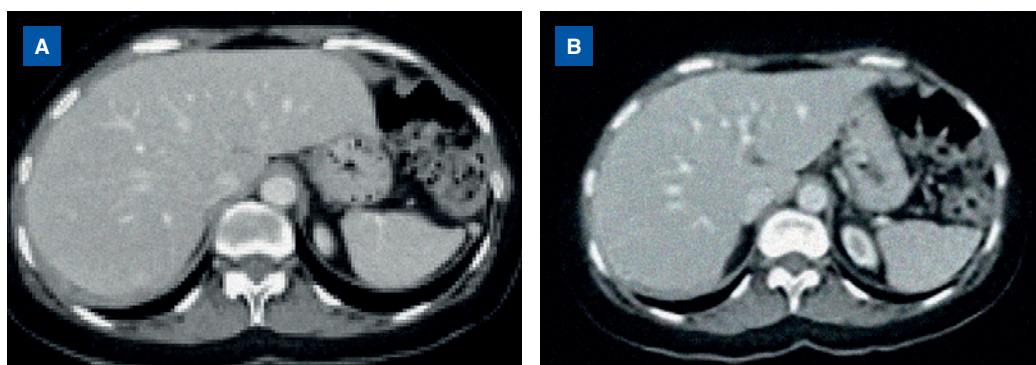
CT Scan. A: August 2016: perihepatic peritoneal implants + ascites. Perisplenic implant. B: January 2017: partial response. Perihepatic implants + ascites.
